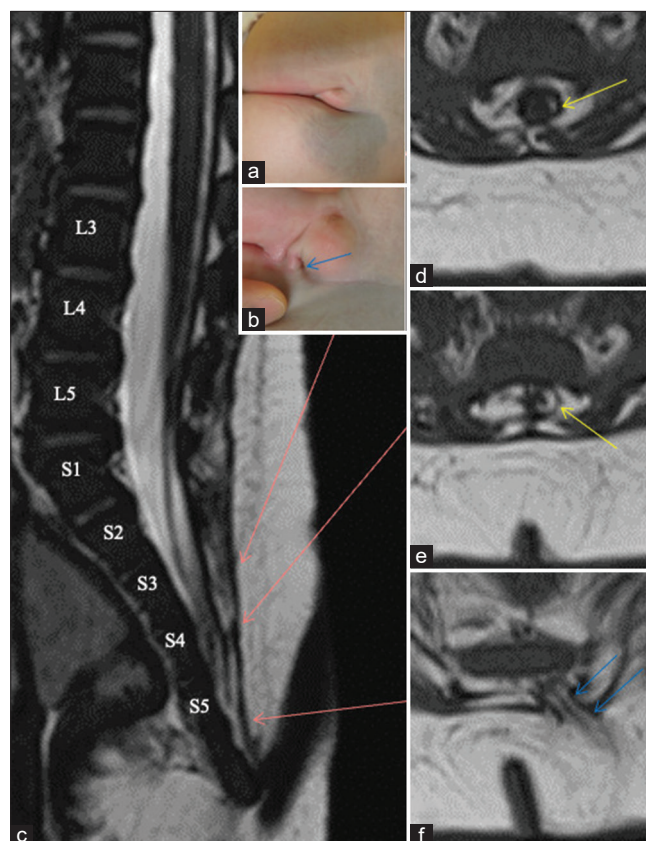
(Patient 1) (a and b) Photographs of the skin lesion, shows a dimple (blue arrows) under the groove on the right side. (c-f) Sagittal view of 3D-hT2WI (c) and axial views of T1WI (d-f). Each slice level of the axial views (d-f) is indicated by red arrows on (c). The caudal cyst wall is partly composed of lipomatous tissue (d,e, yellow arrows). A stalk extending from the subcutaneous fat into the vertebral canal is shown as blue arrows [panel (f)]. 3D-hT2WI: three-dimensional heavily T2-weighted image, T1WI: T1-weighted image.
